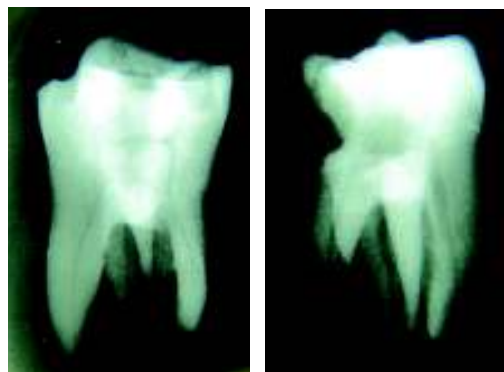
Periapical radiographs of extracted mandibular molars showing radix entomolaris.
